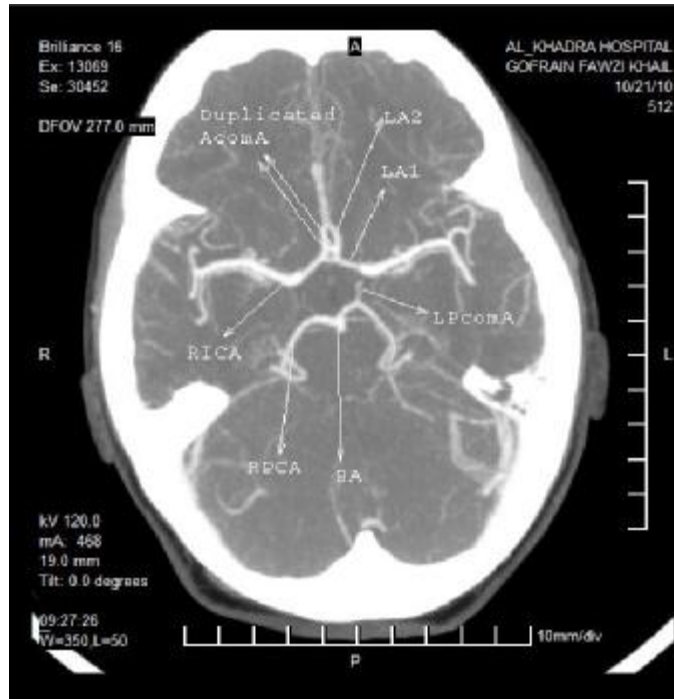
CTA showing duplicated AcomA and missing RPcomA.
